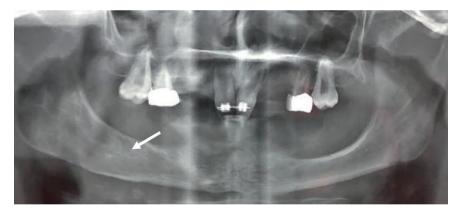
Panoramic x-ray taken 1 month after the impacted tooth extraction and cyst enucleation. White arrow showing the previous position of the impacted tooth.
